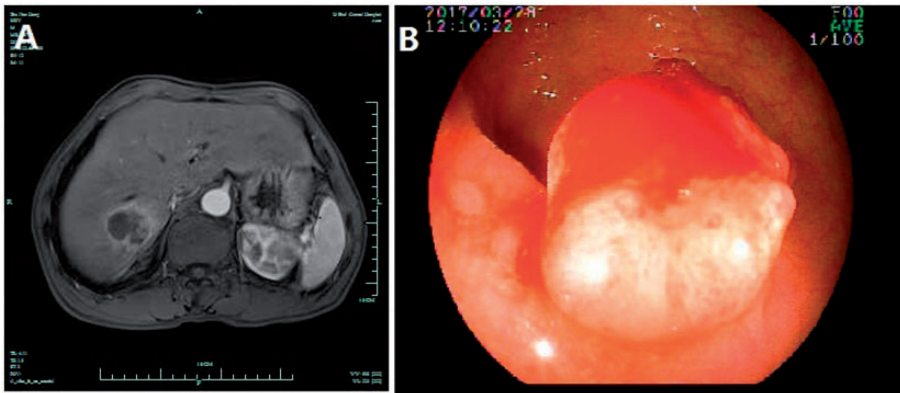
Magnetic resonance imaging and electronic enteroscopy. (a) A liver mass was located in the right lobe and demonstrated significant enhancement in the arterial phase. (b) A wide-based hyperplastic polyp with surface erosion was also observed.
